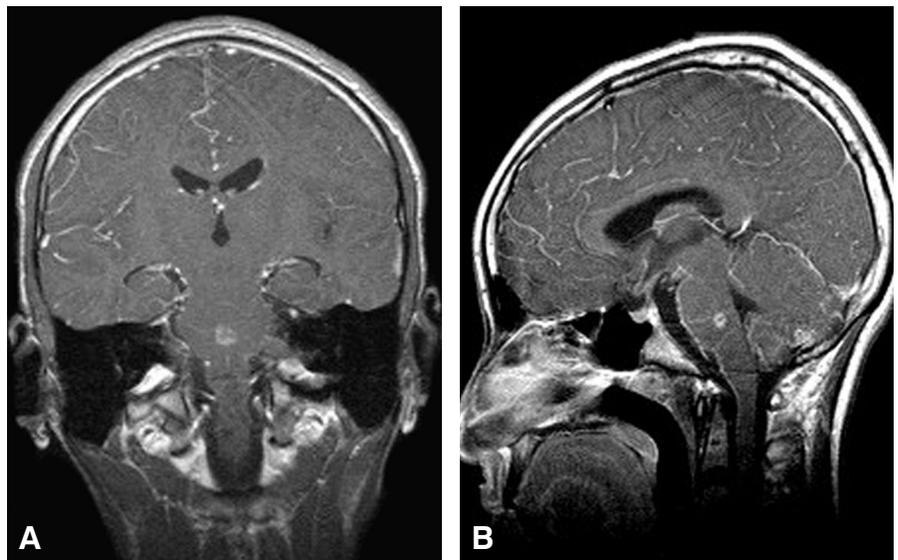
Contrast-enhanced T1-weighted (A) coronal and (B) sagittal MR images showing a large pontine lesion.
